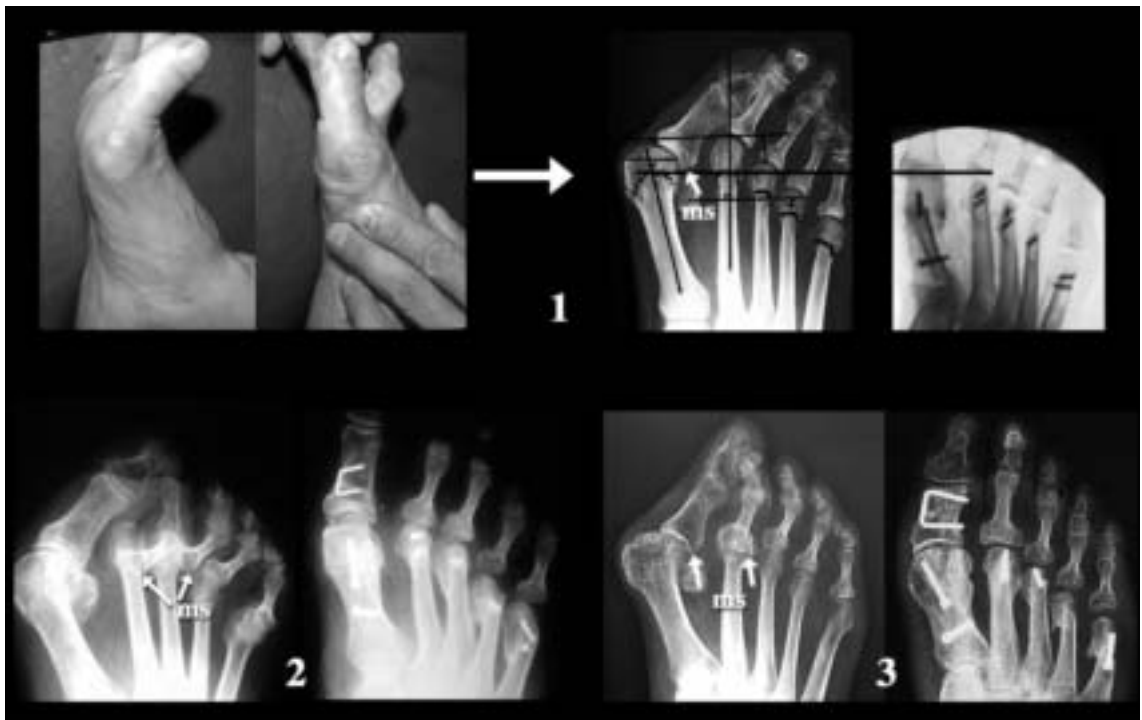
45d2a. Principle IV – The place of a generous shortening of the metatarsals. b) In severe forefoot disorders. 1) The amount of shortening on the dorso-plantar X-ray view.
